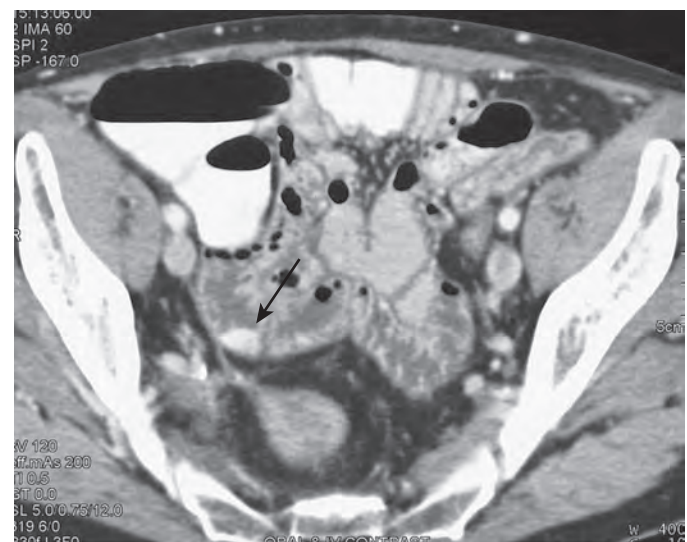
Contrast-enhanced axial CT image. This demonstrates a 9-mm enhancing lesion in the distal small bowel (arrow) ultimately proven to represent a hemangioma.
